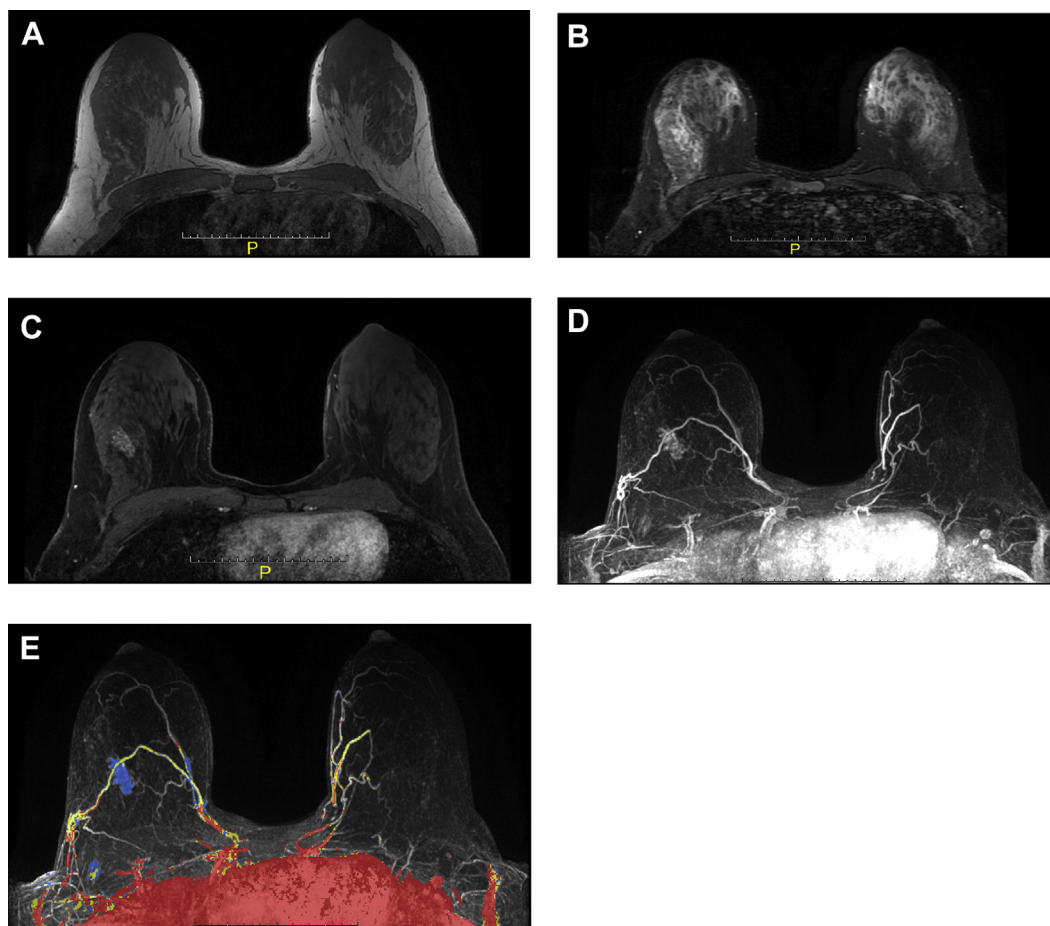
Noncontrast T1 axial breast MRI (A) demonstrates isointense signal in upper outer quadrant of the right breast. Axial T2 STIR (B) demonstrates increased signal in the upper outer quadrant of the right breast. Postcontrast axial T1 fat-suppressed single slice (C), pre/post-contrast subtracted maximum intensity projection (MIP) (D), and kinetic enhancement color overlay MIP (E) demonstrate nonmass enhancement in the upper outer quadrant of the right breast with rapid initial enhancement and persistent delayed enhancement corresponding to the region seen in (A) and (B). MRI, magnetic resonance imaging.
